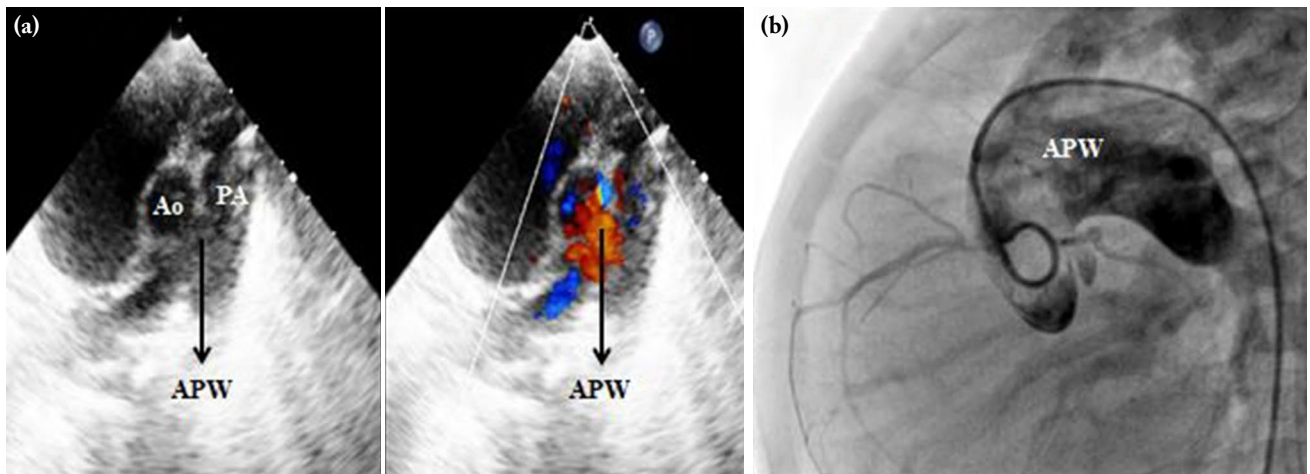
(a) Two-dimensional echocardiography with color Doppler in short axis view shows echo dropout between the aorta and the pulmonary artery indicating APW. (b) Catheterization study (catheter course from descending aorta -PDA-through APW to ascending aorta) demonstrating an APW.
